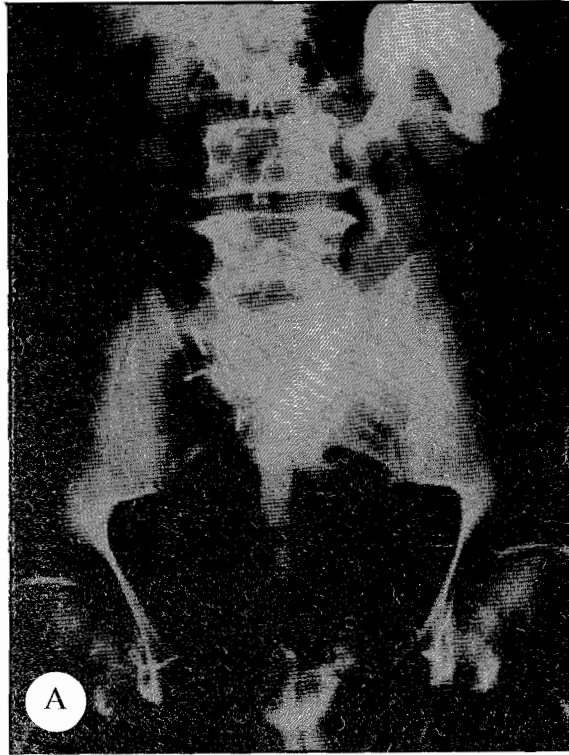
A: Intravenous urogram 2 years postoperative showing hydronephrosis of a solitary left kidney. B: Plain radiograph showing an internal stent following retrograde balloon dilatation and laser ureterotomy. C: Intravenous urogram 6 weeks after removal of the stent showing an improved configuration
